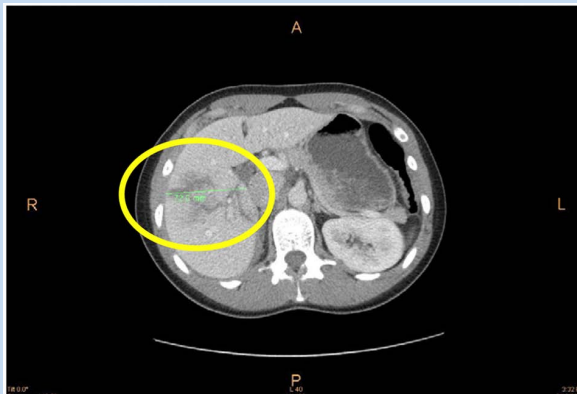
Transverse abdominal/pelvic computed tomography scan at 2.5 hours postinjury. Note the area of linear hypoenhancement involving the right lobe of the liver that extends from the lateral surface to the hilar region indicative of a liver laceration (circled). There was a small amount of intermediate density fluid along the medial posterior surface of the liver indicative of a subcapsular hematoma. Also a trace amount of free fluid was noted along the right paracolic gutter and in the pelvis, which is of intermediate intensity, suggesting a small component of hemoperitoneum.
